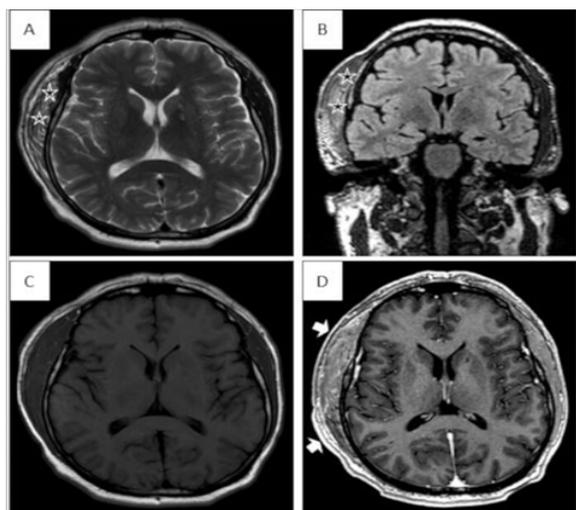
Axial (A) T2-weighted, (B) coronal T2/FLAIR-weighted MRI and (C) T1-weighted native followed (D) T1-weighted contrast-enhanced MRI show expansion and massive high signal intensity (black stars) seen on (A) and (B), as well as significant contrast enhancement (white arrows) involving the muscular compartment of the temporalis muscle on (D) compared with (C).
